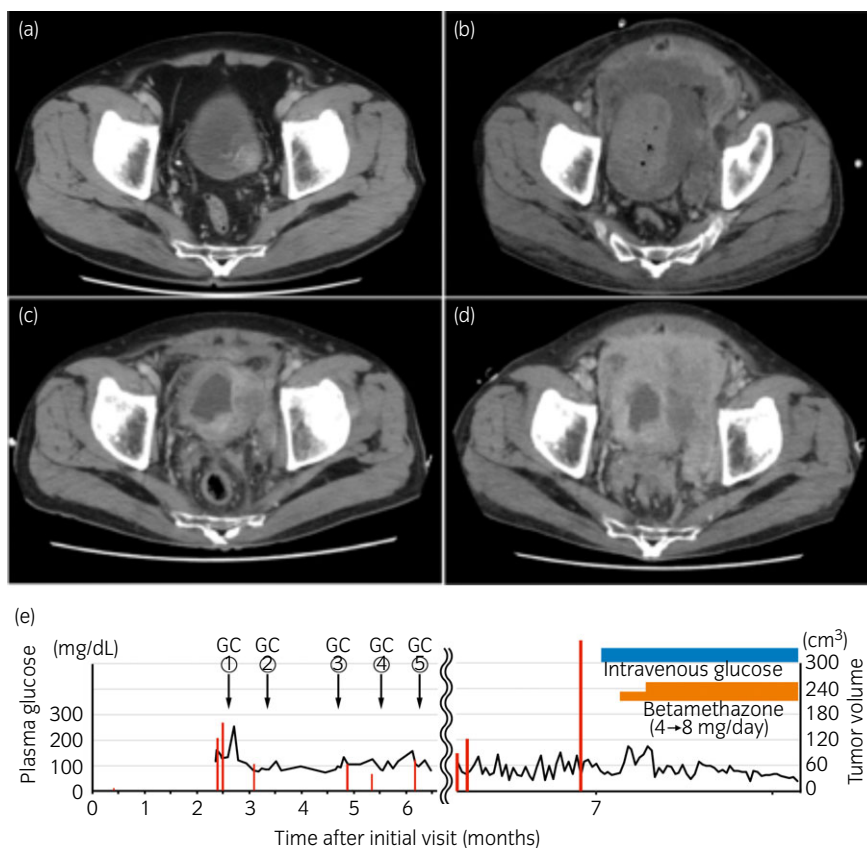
(a–d) Contrast-enhanced CT scans at initial visit (a), pre- (b) and post- (c) chemotherapy settings, and progression (d). (e) Clinical course with regard to plasma glucose (black line) and tumor volume (red columns) from the initial visit to decease. Note the rapid tumor progression and severe hypoglycemia resistant to intravenous glucose injection and betamethasone administration. Tumor volume was estimated using the following formula; $A^2 \times B \times 0.53$, where A and B indicate the largest and orthogonal diameter, respectively, in axial image of CT scan.
